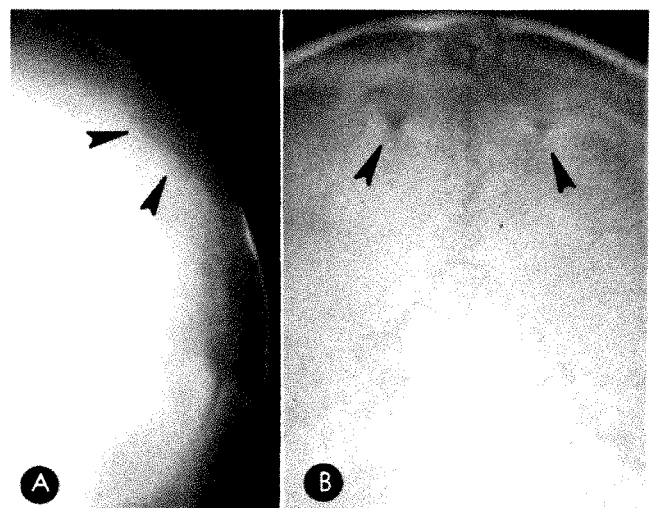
A*, Lateral skull roentgenogram of 2-week-old infant with large parietal fontanelle (arrows). *B*, Frontal view of same patient 9 years later showing only small parietal foramina (arrows).
